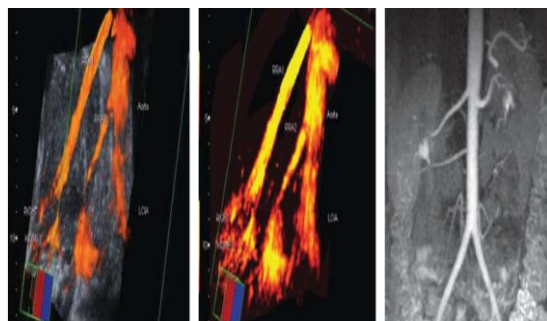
Additional right renal artery that feeds the lower segment of the kidney with uretero-vascular conflict: a - three-dimensional ultrasound angiogram with diuretic stress in the mode MIP; b - three-dimensional ultrasound angiogram with diuretic stress (combination modes MIP and MIN); c - magnetic resonance angiogram.
